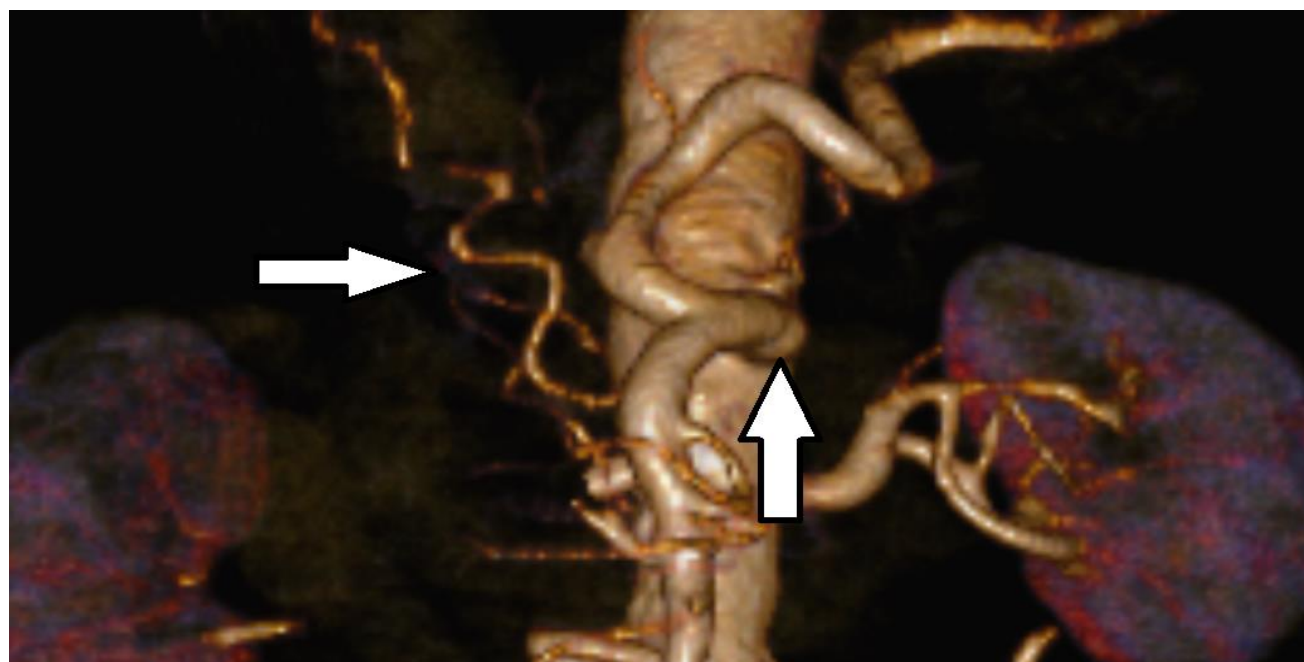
CT angiography; the common celiacomesenteric trunk (up arrow) and the right suprarenal artery (left arrow).
